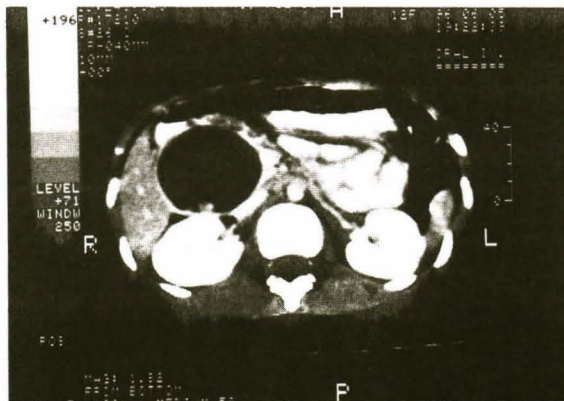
CT scan showing two stones in a choledochal cyst.
